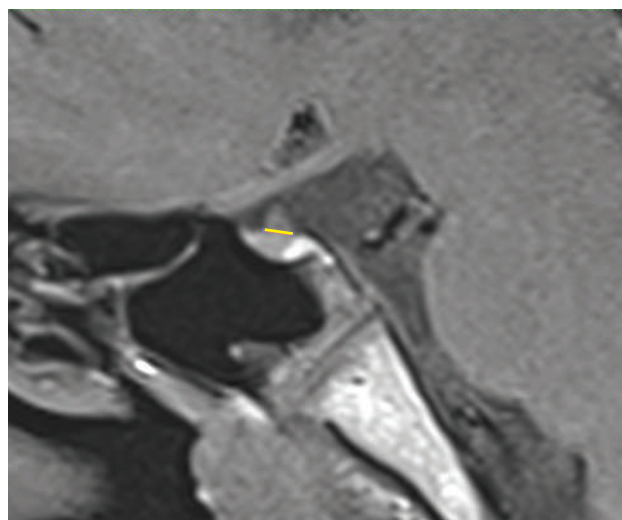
Sagittal T1WI MRI Pituitary showing enlargement of the pituitary stalk, measuring 13 mm in AP diameter.
